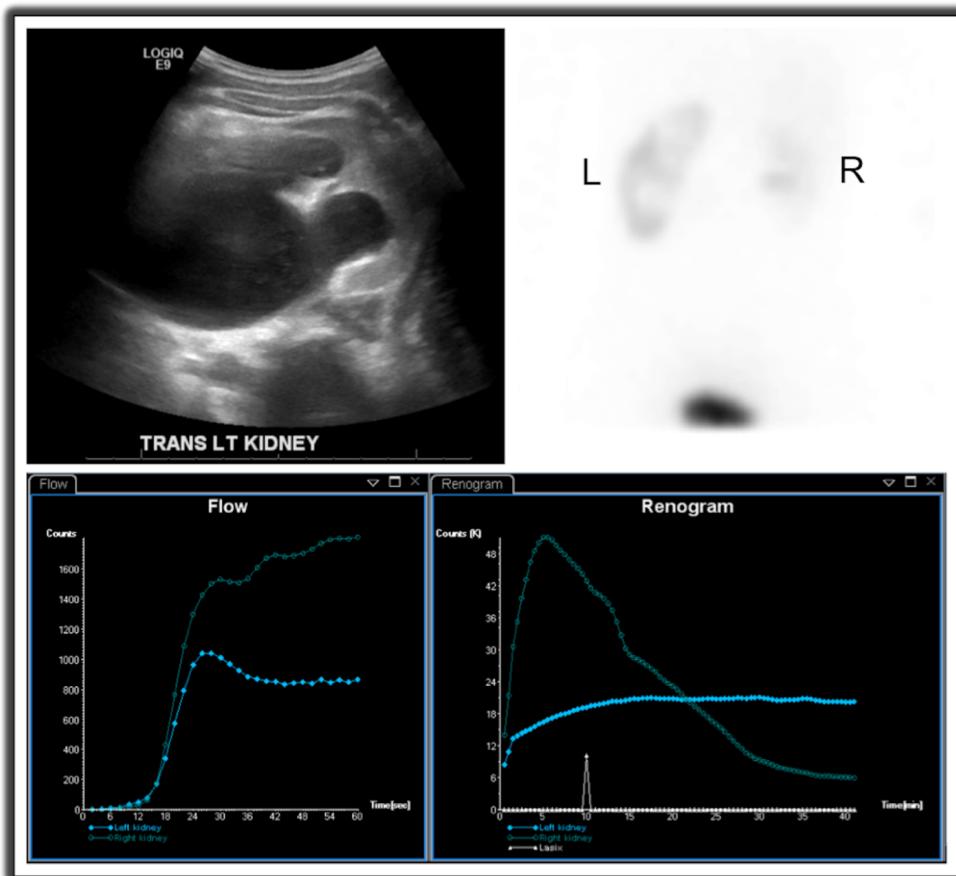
Images of left UPJO. SFU grade 4 hydronephrosis on ultrasound (upper left). Right kidney almost completely drained and left kidney with minimal excretion of radiotracer at 30 minutes (upper right). Decreased function and poor drainage of radiotracer on graphical representation of diuretic renography results (lower).
